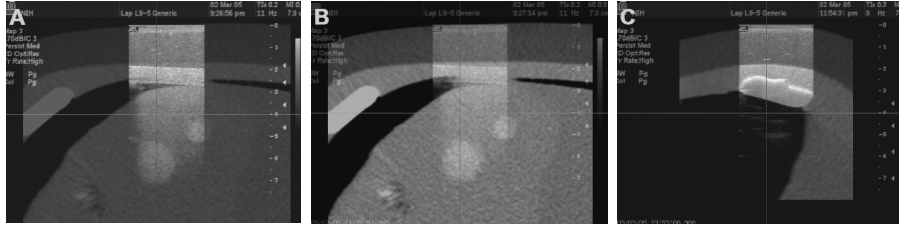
Overlay of real-time laparoscopic US with pre-acquired CT. The two lesions in the US image in (A) become visible in the same position in the CT image (B) after reducing the opacity of the US overlay. (C) shows good agreement of the rib surface between the US overlay and CT image.
